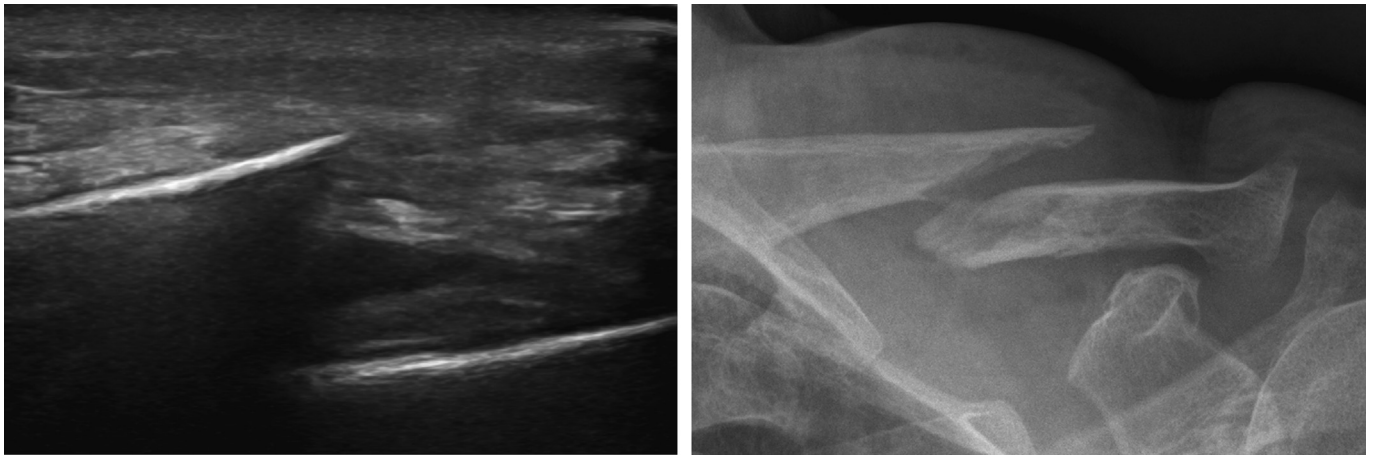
PoCUS image and X-ray of a clavicle fracture.
